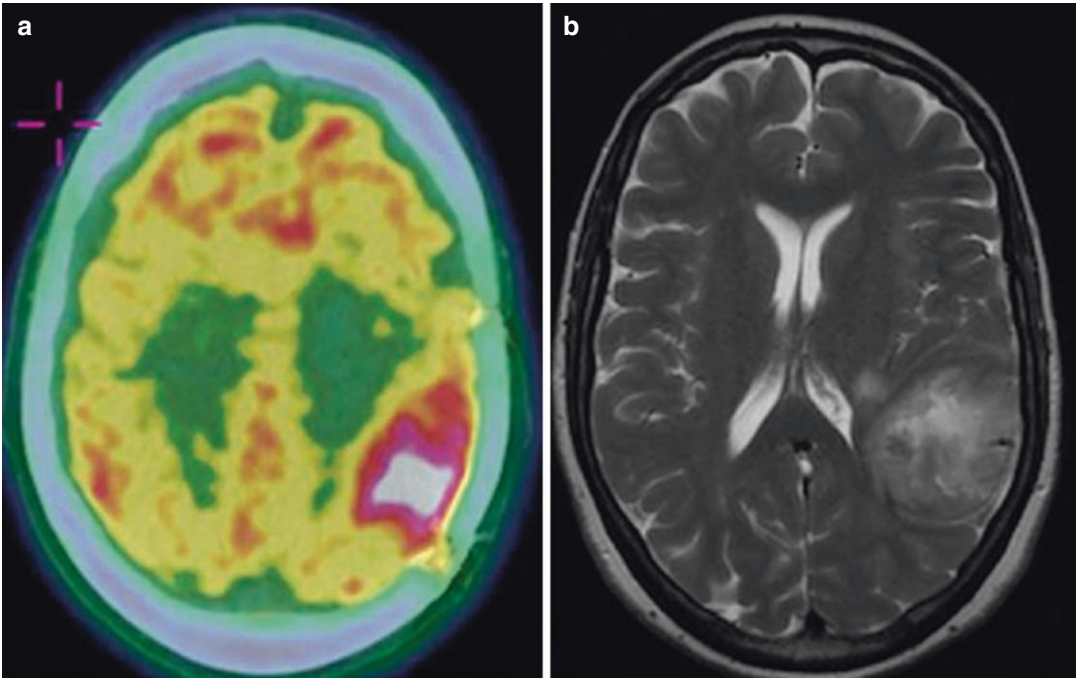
Axial ^{18}F -DOPA PET/CT (a) shows intense uptake in the left parietal region, with abnormal signal intensity and surrounding edema in related T2-weighted MRI view (b), in a patient with glioblastoma
